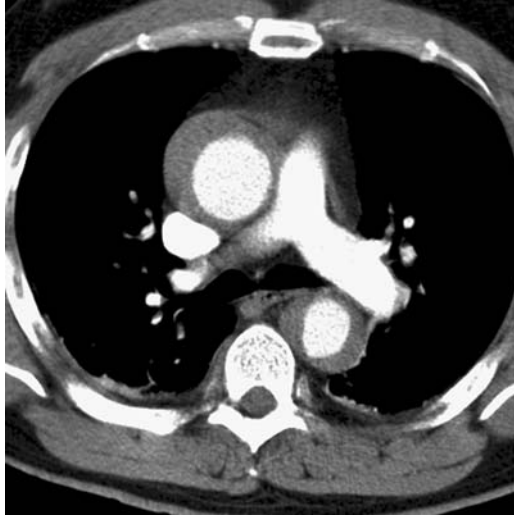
A 60-year-old man was admitted with a clinical presentation of aortic dissection. The CT scan on admittance showed an extensive intramural hematoma affecting both the ascending and descending aorta. At surgery, a primary tear was located in an almost completely fragmented arch demanding an arch resection.
